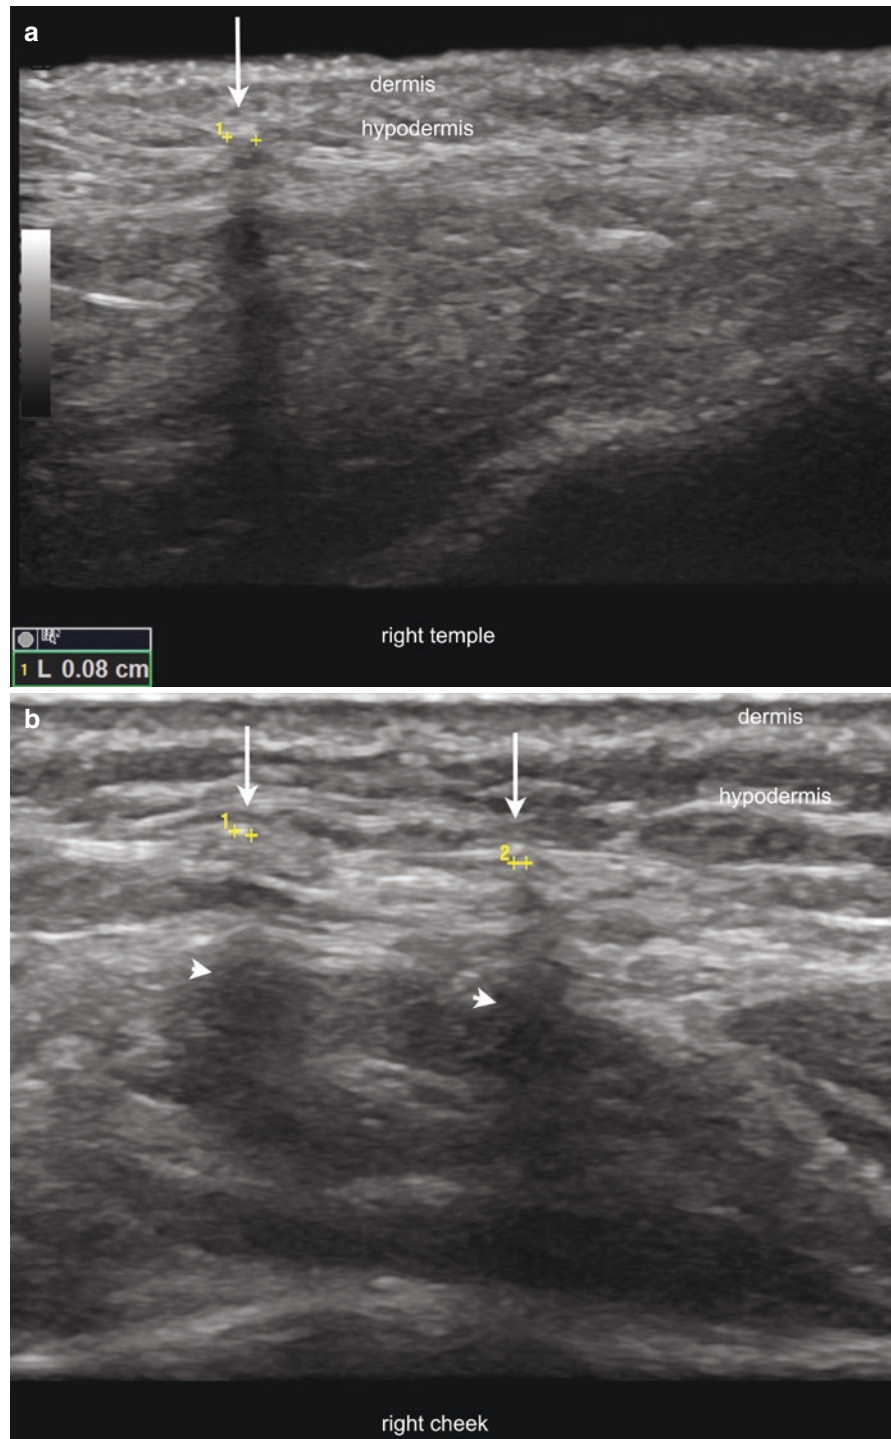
Tensor threads. Ultrasound (greyscale, longitudinal view; (a) right temple; (b) right cheek) demonstrates hyperechoic spots that correspond to a cross-sectional view of polydioxanone tensor threads (between markers; vertical arrows). Notice the posterior acoustic shadowing artifact ((b) short horizontal arrows).
